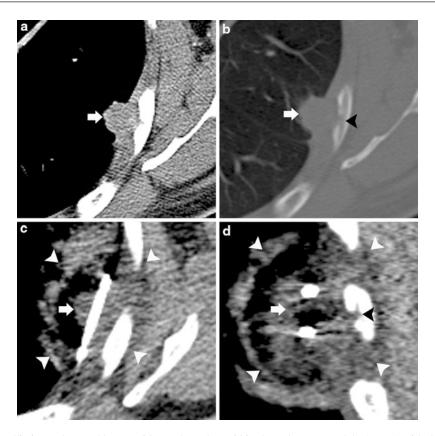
Palliation: 75-year-old man with esophageal carcinoma with pulmonary metastases, who presents with severe left chest wall pain. (a) Axial CT image in soft tissue window shows a left lower lobe pulmonary nodule (*arrow*) with associated pleural thickening. (b) Axial CT image in bone window shows the left lower lobe nodule (*arrow*) eroding into the adjacent rib (*arrowhead*), accounting for the patient's pain. (c) Axial ablation CT image demonstrates interval placement of a cryoprobe
